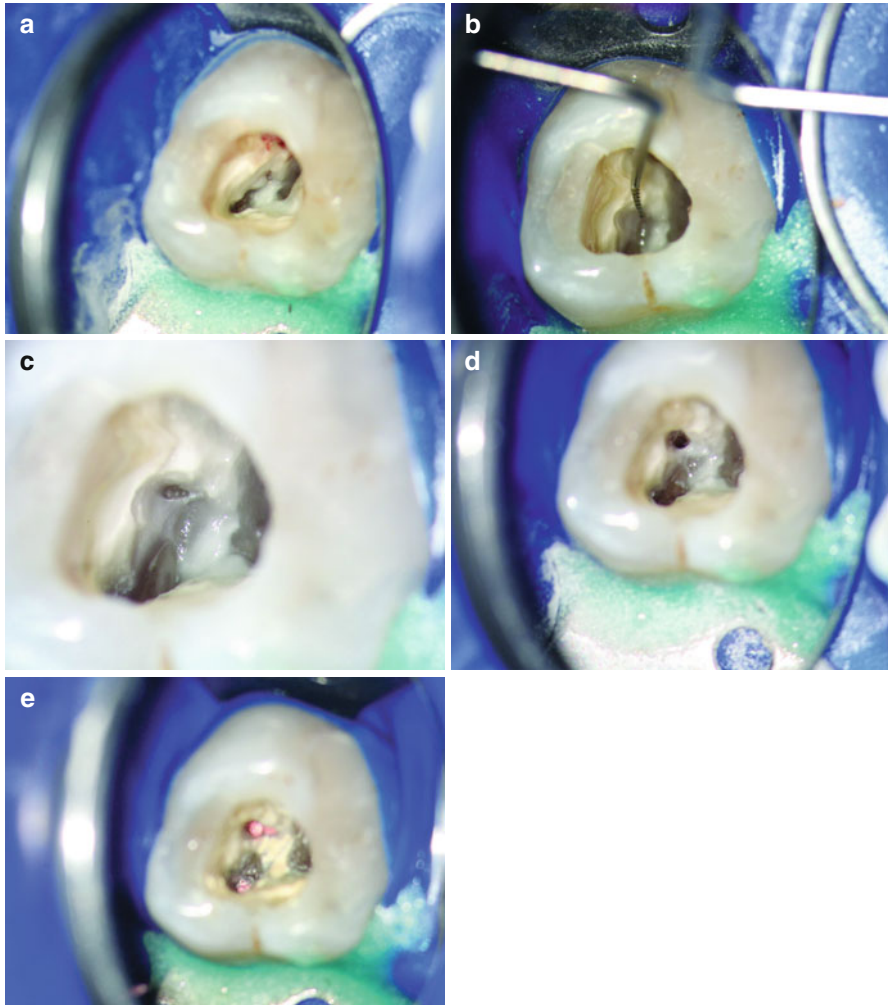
Identification and instrumentation of a calcified MB2 of a first maxillary molar. Access cavity overview with dentin obstructing the canal entrance to MB2 (10× magnification). (b) Canal identification after ultrasonic dentin removal (10×). (c) Initial preparation of MB2 for straight-line access (16×). (d) Completely instrumented MB2 canal prior to root filling (10×). (e) Root fillings in mesiobuccal canals (10×) (Images a, b, and d from Setzer and Kim [38]; with permission)
